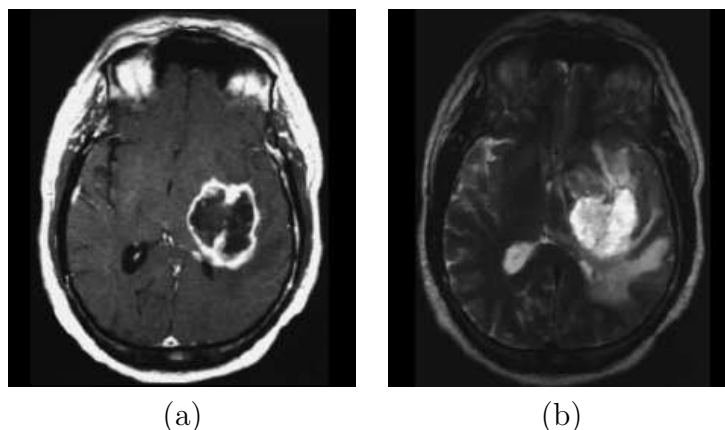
Glioblastoma multiforme. a) Contrast enhanced axial T1-weighted of a ring enhanced tumor (necrotic). b) Axial T2-weighted image of the same tumor showing the surrounding edema [Wen et al., 2001].
